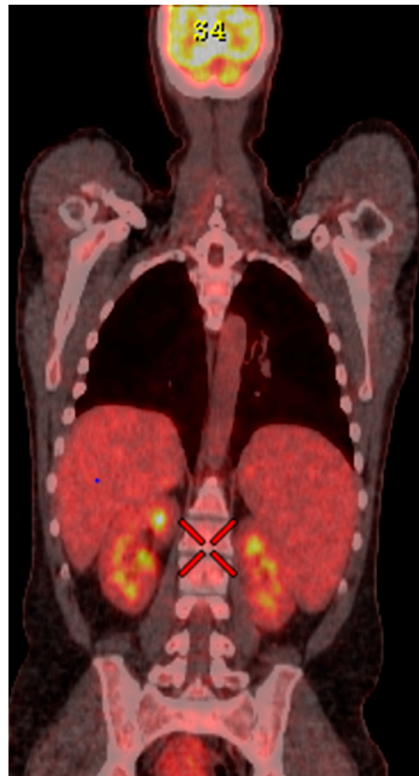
18-FDG-PET shows diffuse metabolic activity within the liver, spleen, and whole bone marrow. Characteristics: coronal Ex: 14,321, Se, 12 STATIC, P: 68,36, DFOV: 172.9 × 98.8 cm, M: 13.11 kBq/mL.
